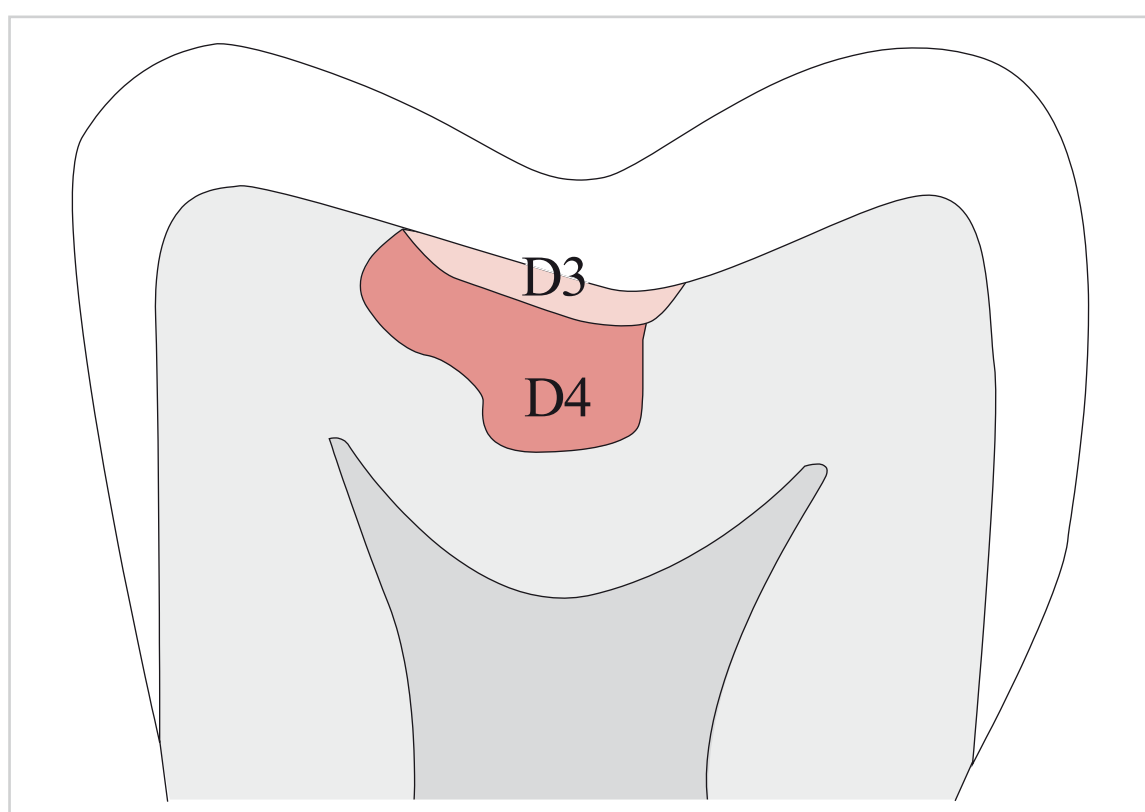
Occlusal caries stages: radiographic diagnosis of D1 to D2 occlusal caries in the enamel is not possible. D3: carious lesion in the outer half of the dentin; D4: carious lesion in the inner half of the dentin. (From: Weber T. *Memorix Zahnmedizin*. 3rd ed. Stuttgart: Thieme; 2010.)
